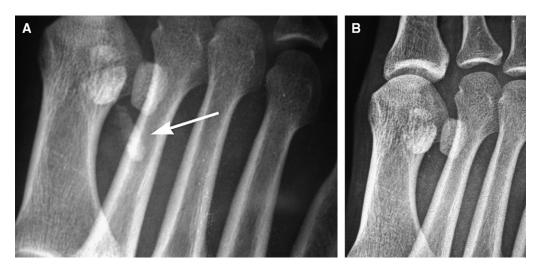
(A) A 53-year-old man with pain in the forefoot. Oblique radiograph of the foot shows a long calcification below the first metatarsal (arrow). Calcification was treated by means of sonographically guided lavage and aspiration. (B) Immediately after treatment, the calcification disappeared and symptoms resolved.
